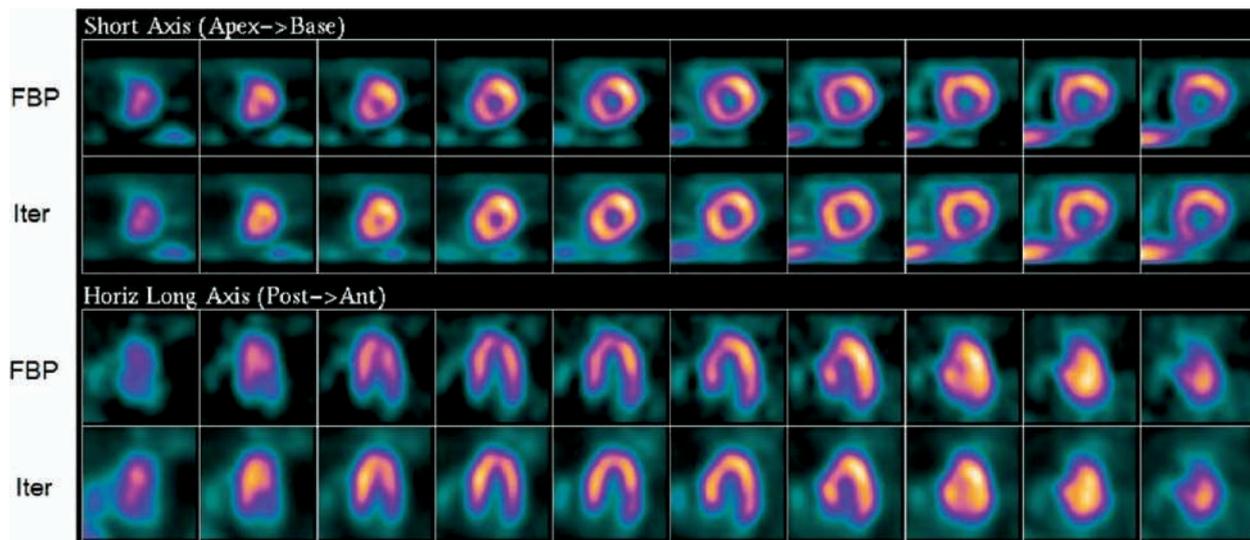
Example of FBP and iterative (*Iter*) methods for SPECT reconstruction in the patient from Figure 4. The inferior wall defect is less pronounced with the iterative method. *Horiz*, Horizontal; *Post*, posterior; *ant*, Anterior.
